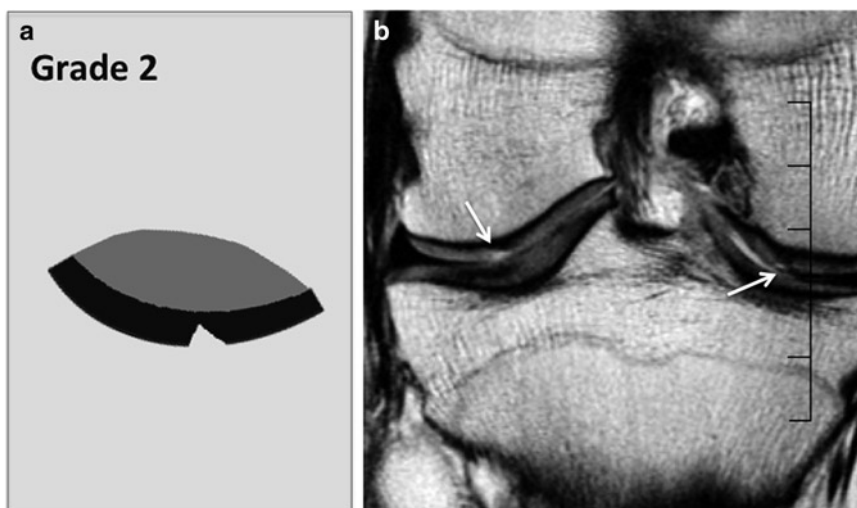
Whole-Organ-MRI-Score (WORMS) grade 2 lesion.* Graph of grade 2 knee cartilage lesion (a) and coronal proton density weighted fast spin echo sequence of the knee (b) showing two cartilage WORMS grade 2 lesions at the medial and lateral femoral condyles. The focal lesions measure less than 1 cm and are less than full thickness (arrows).
